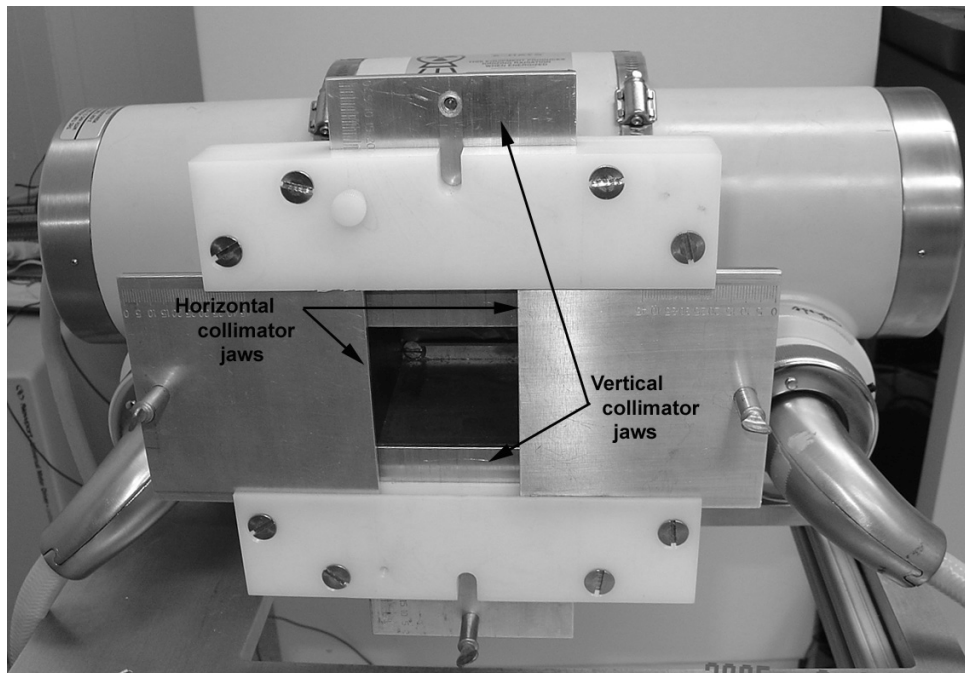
Photograph of the Varian x-ray tube with adjustable vertical and horizontal jaws indicated on the image. (Photograph courtesy of Dr. Randolph McKinley)
